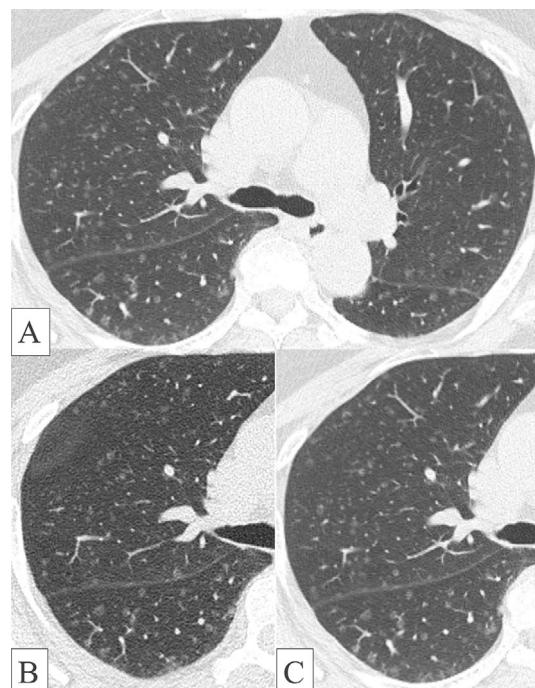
Chest computed tomography (CT) showed diffuse bilateral minute ground-glass opacities on initial consultation. The nodules were randomly distributed, measuring up to 5 mm in diameter, and some had central lucency (A, B). The number of nodules increased four months later (C).
